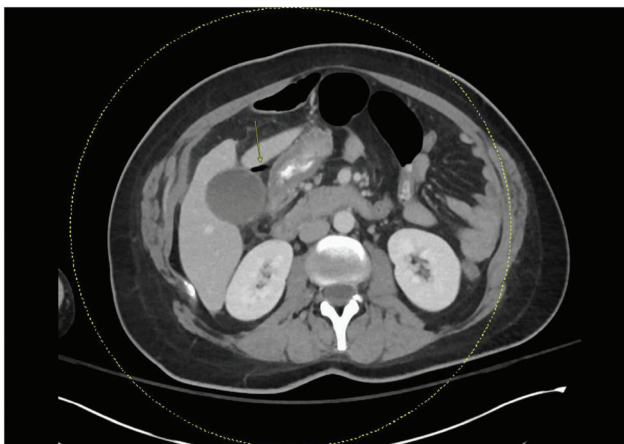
Patient A's axial CT of the abdomen and pelvis demonstrates thickening of the duodenal bulb, a focus of free air adjacent to the postbulbar duodenum (yellow arrow), extraluminal contrast, as well as stranding and small fluid in the right upper quadrant, consistent with duodenal ulcer perforation. CT, computed tomography.
